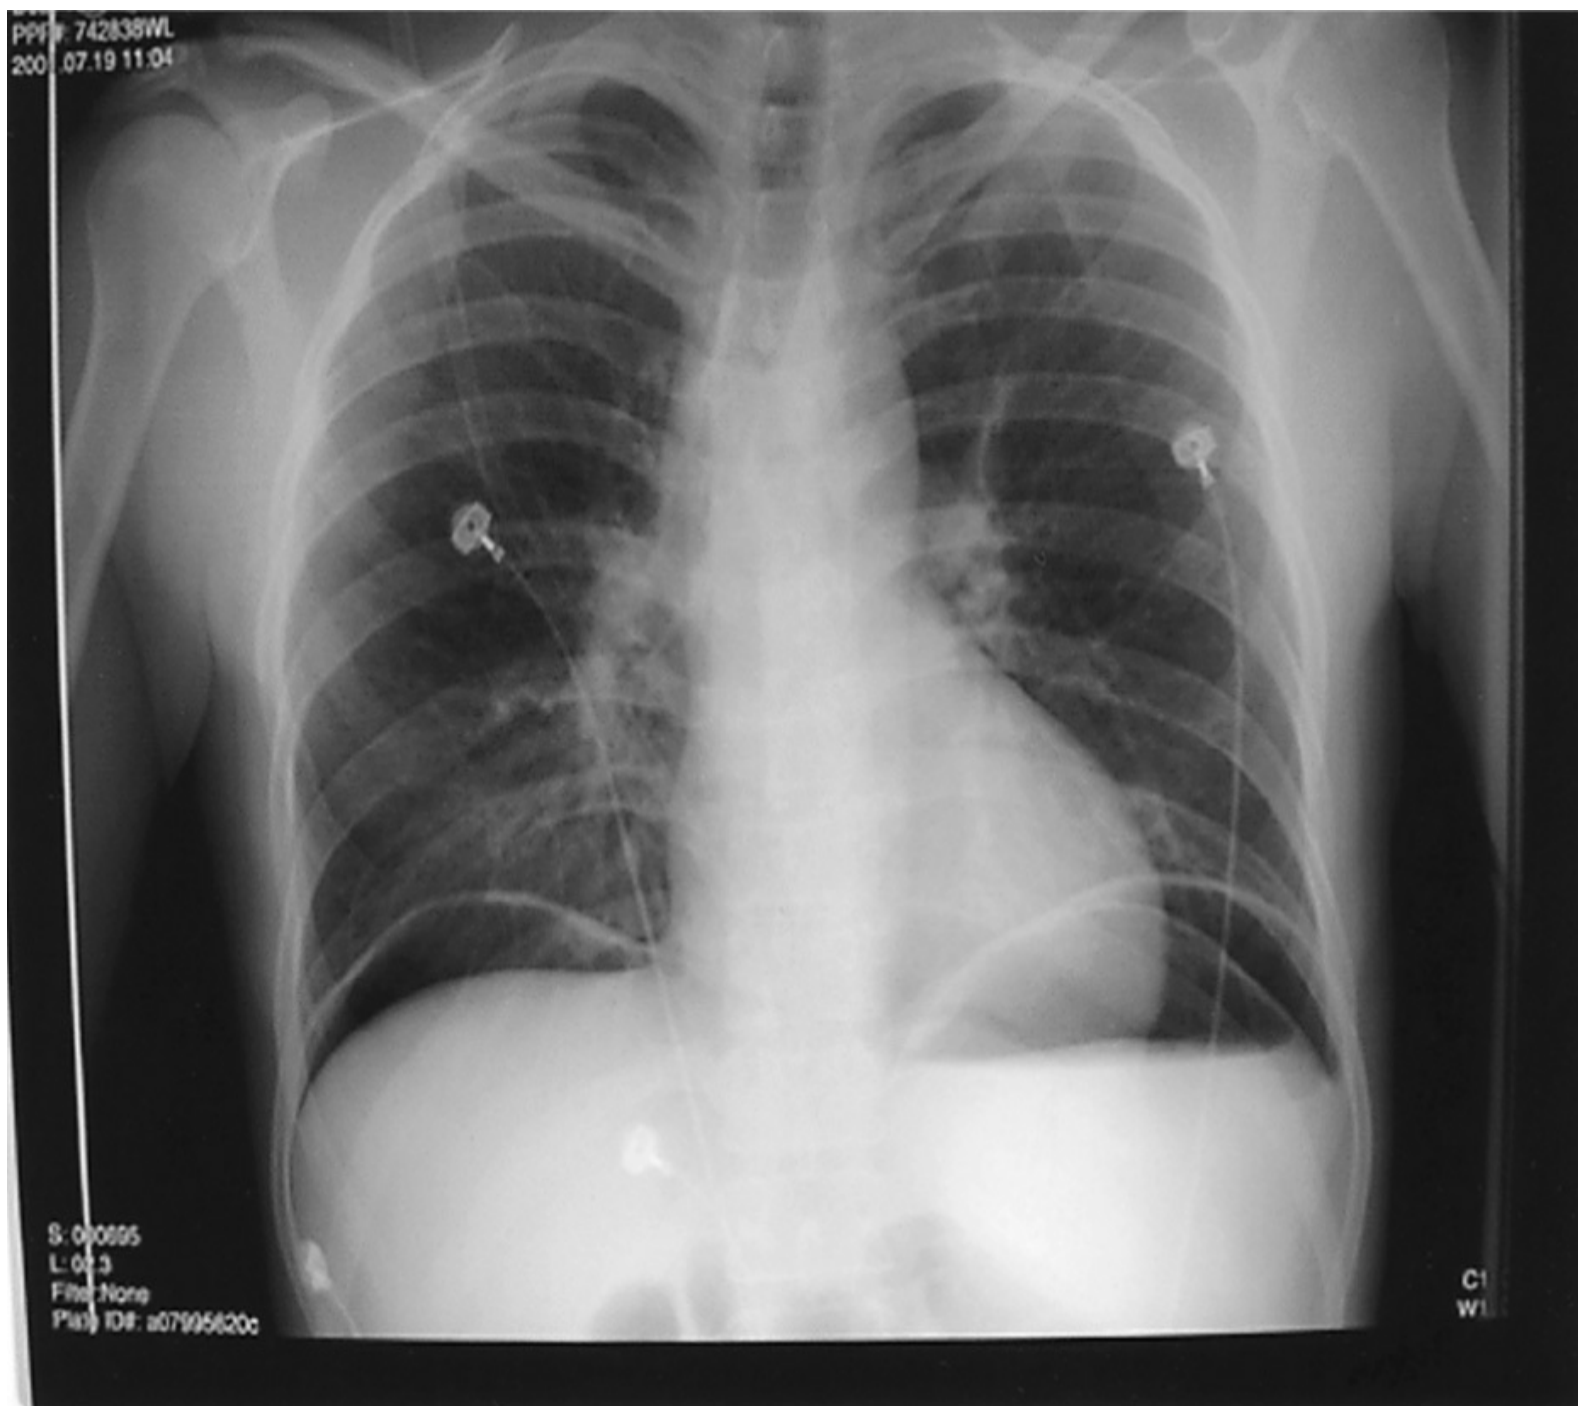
Upright anteroposterior chest radiograph demonstrating pneumoperitoneum from a perforated peptic ulcer. (Reproduced, with permission, from Stone C, Humphries RL, eds. *Current Diagnosis & Treatment Emergency Medicine*. 7th ed. New York: McGraw-Hill; 2011.)
